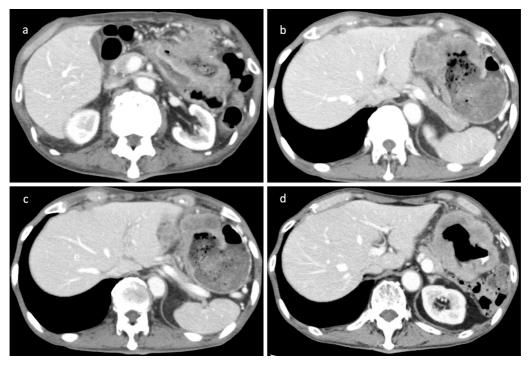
Contrast-enhanced CT images through the treatment course before palliative gastrectomy. CT images at the diagnosis (a, b, c) and after 10 cycles of carboplatin and etoposide chemotherapy (d). CT: computed tomography
